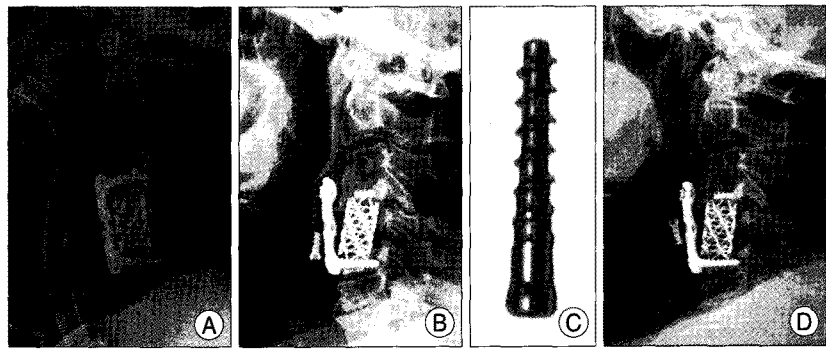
A : Immediate postoperative radiographs showing anterior cervical plating at the C4-C6 level. B : Lateral cervical spine X-ray demonstrating the fracture and dislocation of the upper screws. C : The screw that the patient coughed up. D : Lateral cervical spine X-ray 6 months later, showing that the position of the remaining screw had changed slightly.
